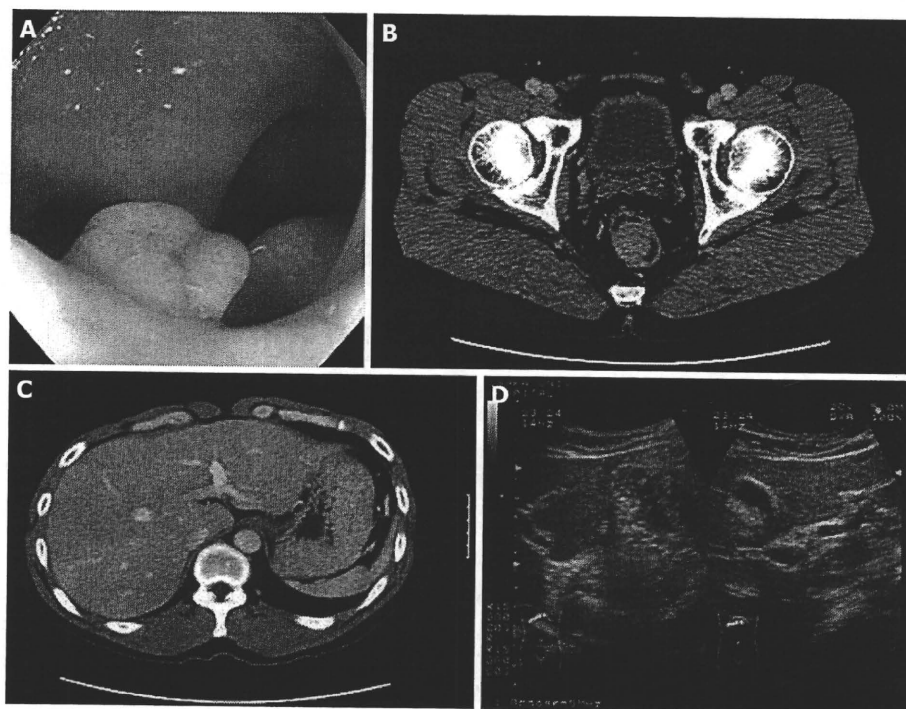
Preoperative colonoscopy and image examinations. A: Colonoscopy showed an elevated yellowish lesion with a slight central depression of which size was 30 mm in diameter, in the lower rectum; B: A tumor was present on the right wall of the lower rectum by computed tomography (CT) scan; C: Abdominal CT failed to show any obvious abnormalities in the liver; D: No obvious lesions were detected in the liver by ultrasonography.
